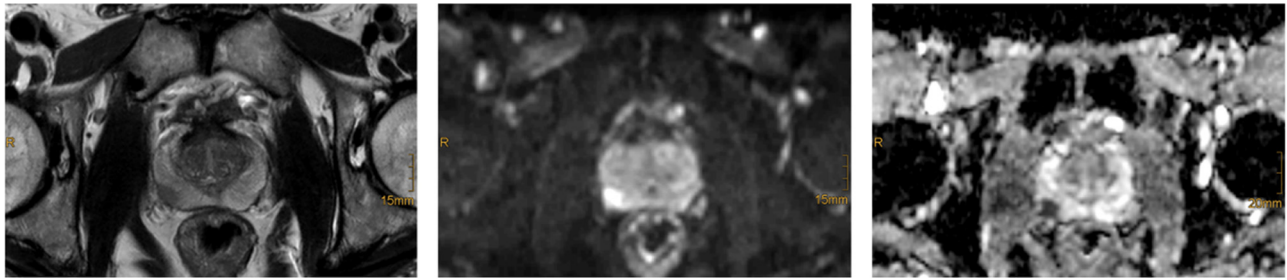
MR-images of prostate cancer (Gleason-Score 4 + 4 = 8). Left: Transversal T2 weighted image with well margined hypointense lesion in the right posterior peripheral zone. Middle: Transversal diffusion weighted image (DWI) with hyperintense lesion on b-800 images. Right: Corresponding hypointensity in the apparent diffusion coefficient (ADC) map.
